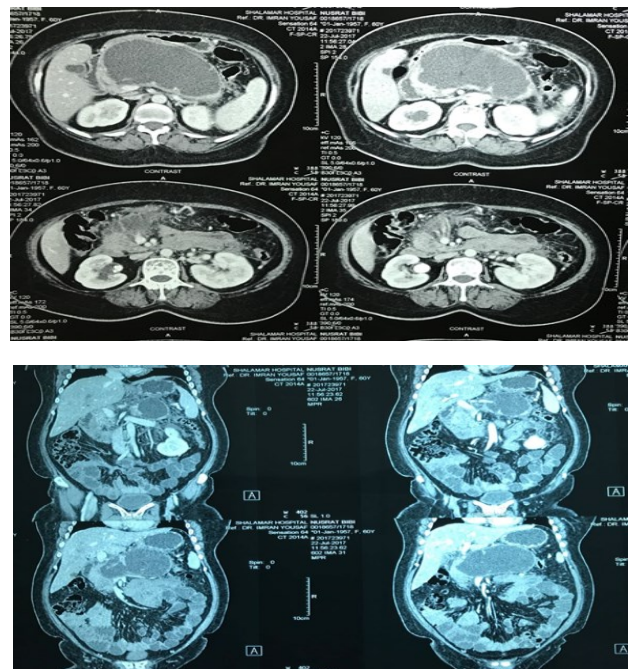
CT scan film showing axial and coronal section.
